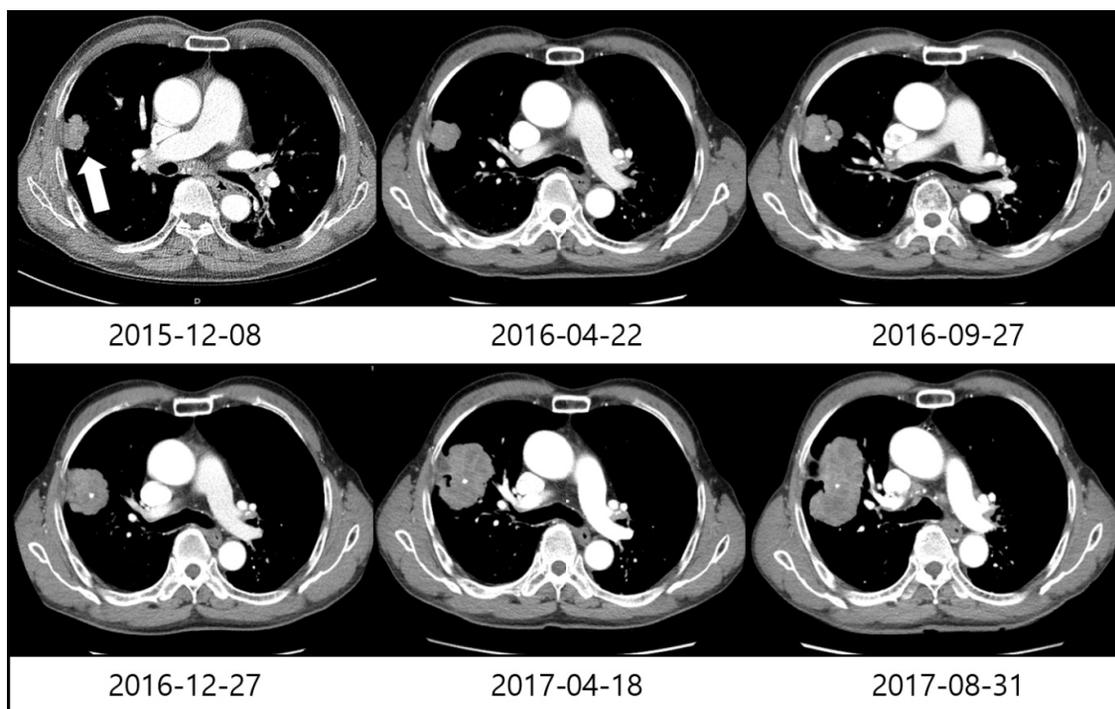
A chest CT scan dated December 8, 2015 revealed an approximately 3.6 cm solid nodule in the upper right lobe. A follow-up chest CT scan dated April 22, 2016 showed stable disease of the mass after 15 weeks of non-conventional treatment. The sequential chest CT scans demonstrated the progression but no metastatic regions including the mediastinal lymph nodes.
